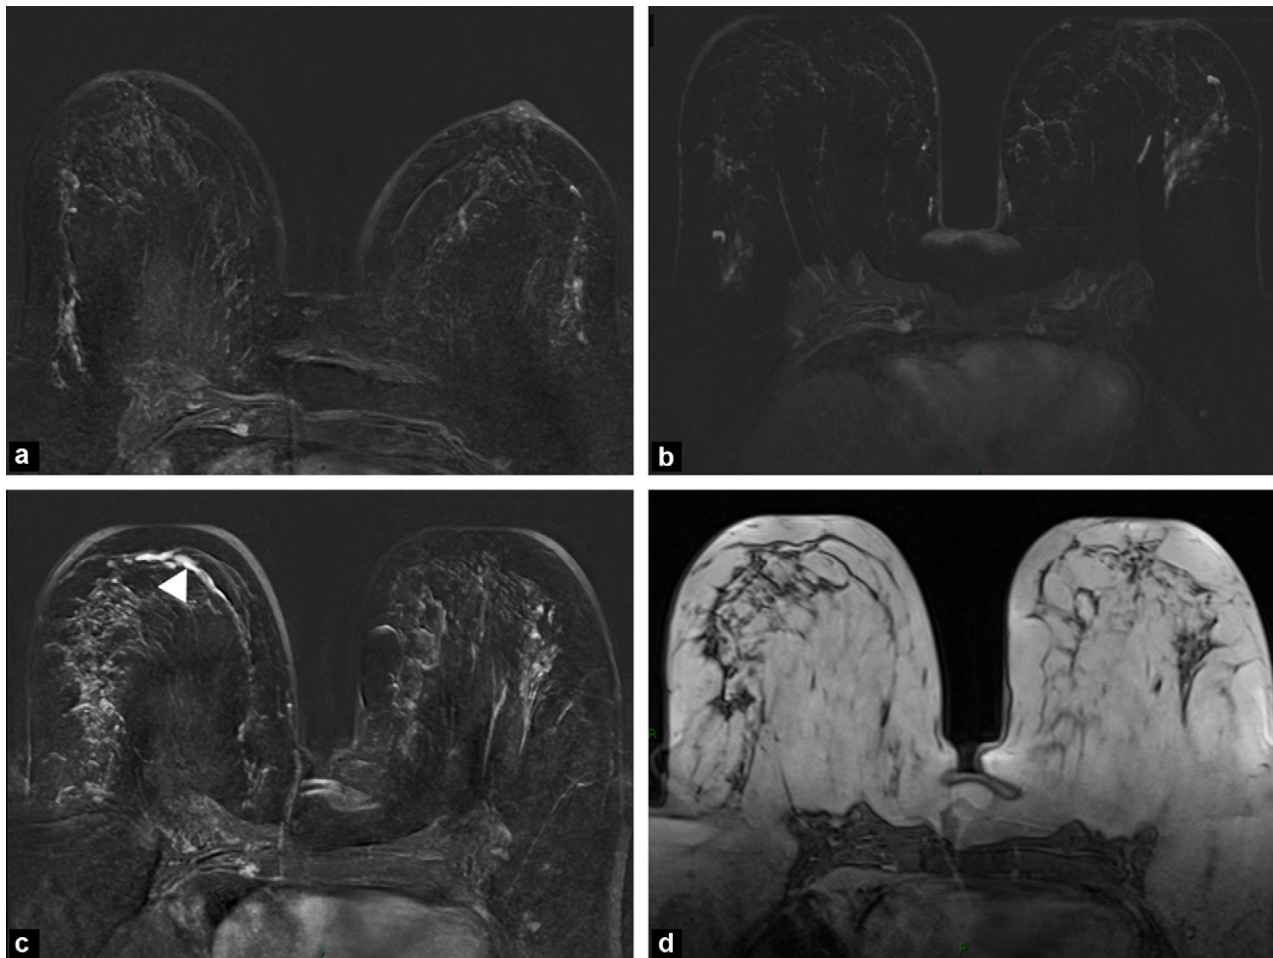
Breast MRI at 4 months, T1-weighted injected with subtraction (a) and breast MRI at 8 months, T1-weighted injected with subtraction (b). Initial breast MRI axial T1-weighted injected with subtraction (c), initial breast MRI T1-weighted (d).
